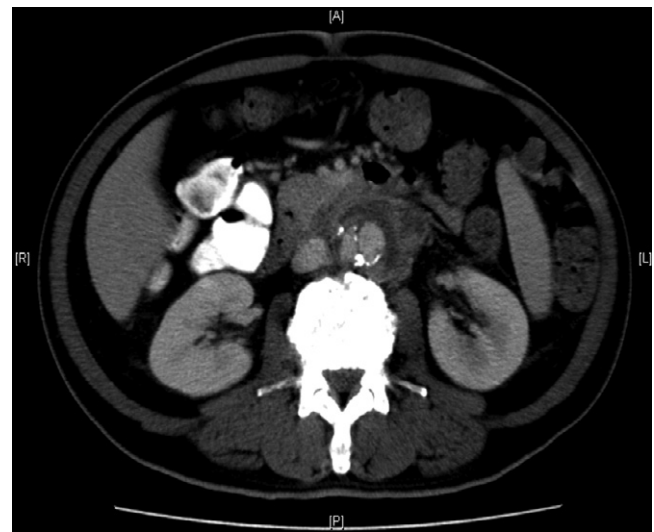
Pre-operative CT scan showing the infra-renal aneurysm.
